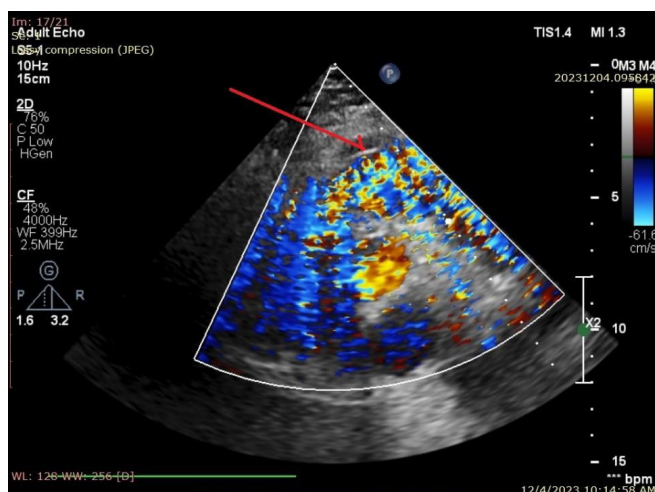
Postoperative echocardiography showing the pulmonary valve during systole. The red arrow indicates the monocusp of the pulmonary valve, which is constructed from pericardium
